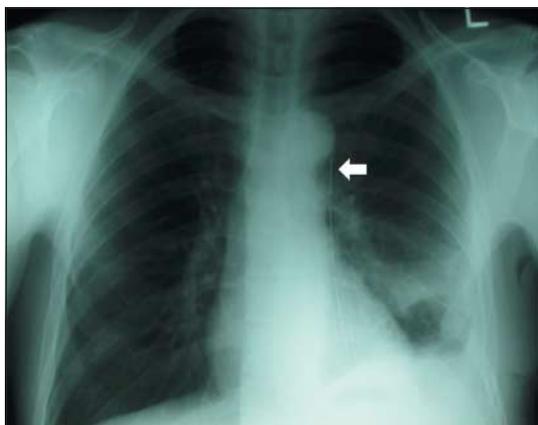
(top) Chest radiography shows unremarkable appearance of intercostal drain (arrow), apart from its medial location. (bottom) Axial computed tomography shows drain (arrow) is located in subcutaneous tissues. More superior images showed that the drain terminated in this superficial position
